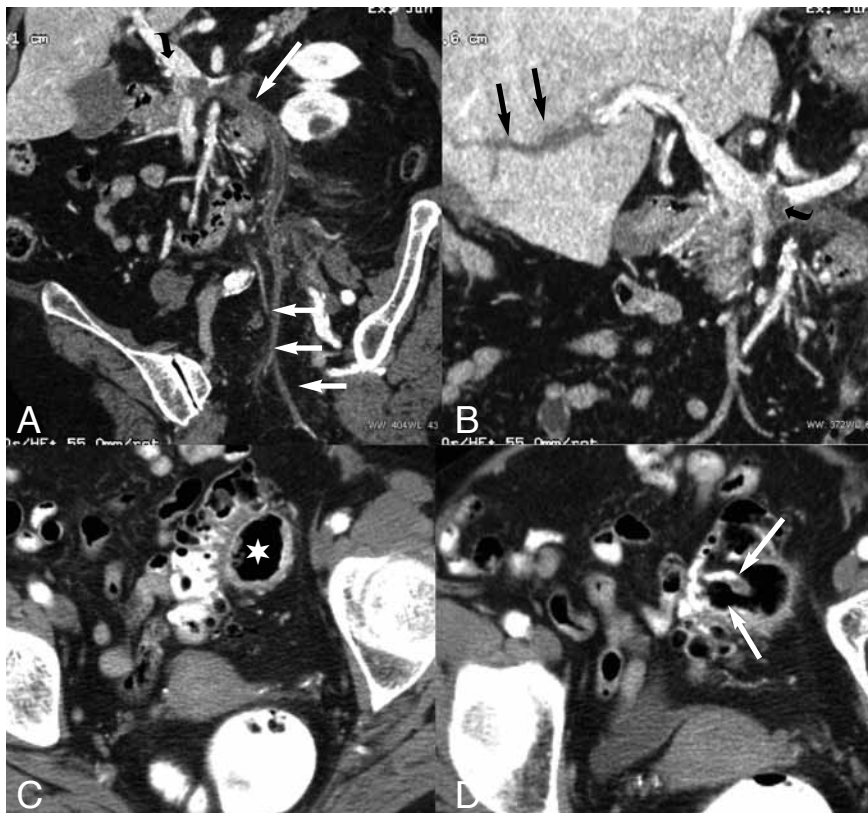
A: curved reconstruction of the same examination. Thrombus is seen in the peripheral branch of the sigmoid vein (small white arrows), extending into the inferior mesenteric vein (large white arrow). Distal end of the thrombus in the lower portal vein (curved black arrow). B: curved reconstruction of the portal vein and left branches. Distal end of the thrombus in the lower portal vein (curved black arrow) and thrombus in the left branches of the portal vein (black arrows). C: CT scan performed 2 years earlier: The large pericolic air-filled cavity was already present (star). D: this organized collection is in communication with the colon lumen through more than one diverticulum (2 are seen on this slice, white arrows).
